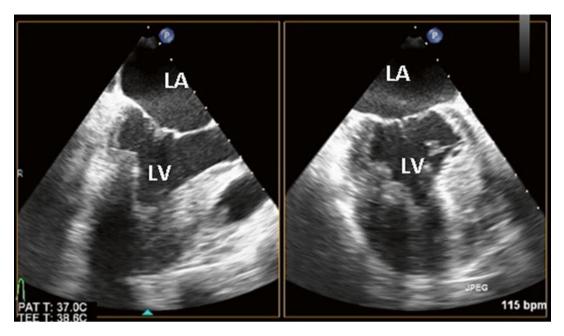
Two-dimensional transesophageal echocardiography (2D TEE), x-plane view, showed LV apical hypertrophic cardiomyopathy with normal function
